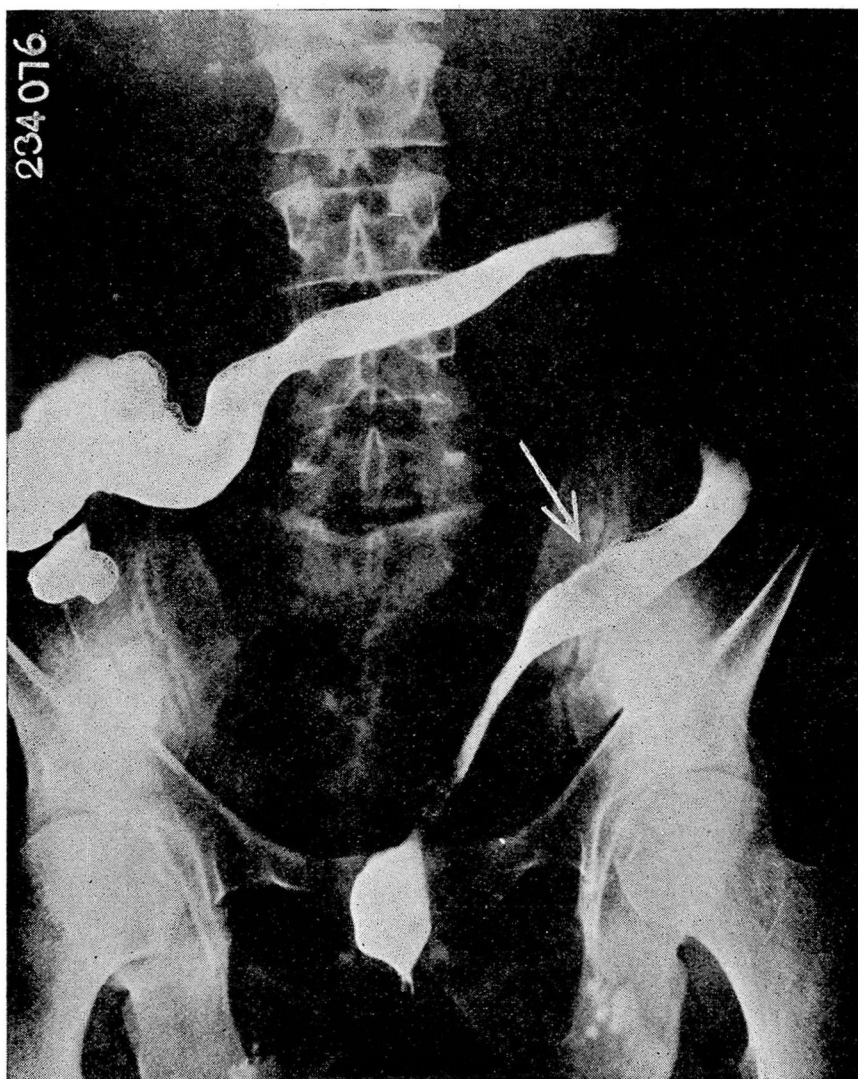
Extensive chronic ulcerative colitis subsequent to ileostomy. Colectomy now being considered because of evidence of polyp formation in sigmoid colon which was not present during former roentgen examinations.
